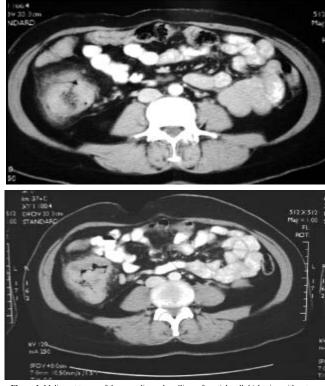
Malignant tumor of the ascending colon. Circumferential wall thickening with extramural spread (A) and paracolic lymphadenopathy (B), all correctly detected on the CT scan.
